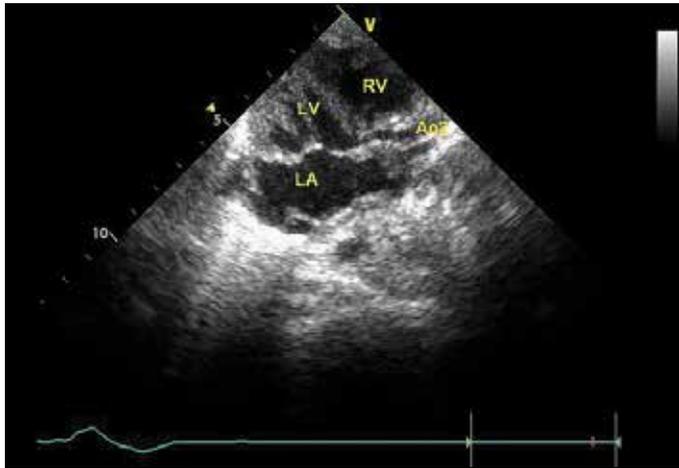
Echocardiogram showing aorta-2 connecting the left ventricle
